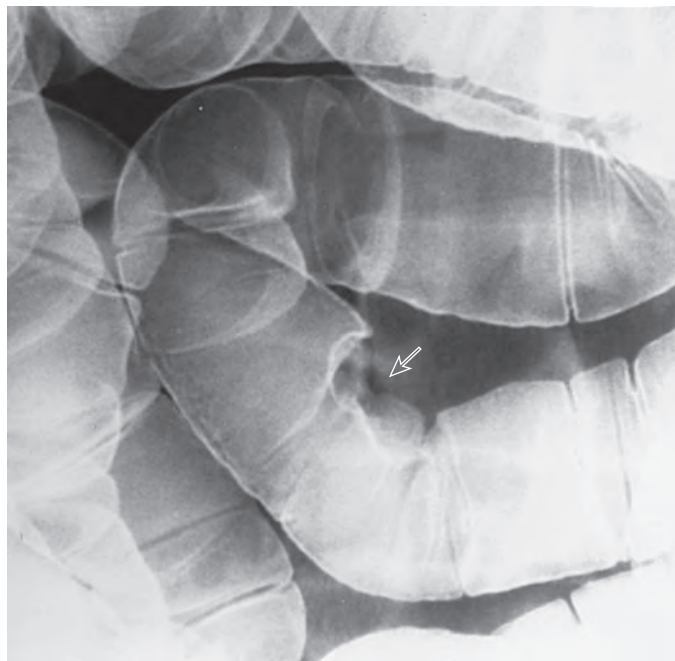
Hemangioma. Double-contrast enteroclysis demonstrates a 1.5-cm, slightly lobulated mural nodule (arrow) in a patient with occult gastrointestinal bleeding. A hemangioma was confirmed at surgery. (From Maglinte DD, Lappas JC, Kelvin FM, et al: *Small bowel radiography: How, when, and why?* Radiology 163:297–305, 1987.)
